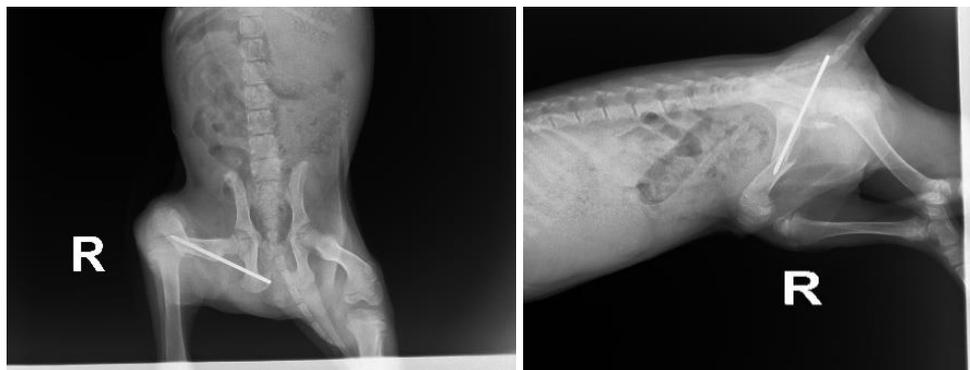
Postoperative I radiographic examination showing ventrodorsal (left) and lateral (right) views. Proximal migration of the intramedullary pin is observed, resulting in failure of union of the femoral diaphyseal fracture.
